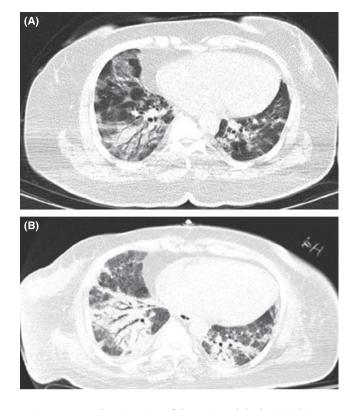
Chest imaging of the patient. (A) The initial CT scan of the patient showing patchy ground-glass opacities in favor of COVID-19 infection. (B) GGO region replaced by alveolar consolidation
